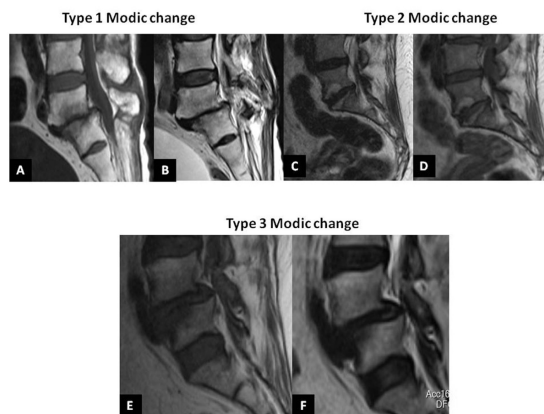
Modic type I change: A - Mid sagittal MRI section (L5-S1) showing hypo-intense signal intensity on T1 weighted image (T1WI) and B - Para sagittal MRI (L5-S1) showing hyper-intense bone marrow lesion on T2WI. C and D - MC type II lesion (L5-S1) showing hyper-intense signal intensity on T1WI and T2WI parasagittal sections, respectively. E and F - Type III MC (at L4-L5) showing hypo-intense signal intensity on both T1WI and T2WI parasagittal sections, respectively. G and H - Type III MC (at L4-L5) showing hypo-intense signal intensity on both T1WI and T2WI parasagittal sections, respectively.
